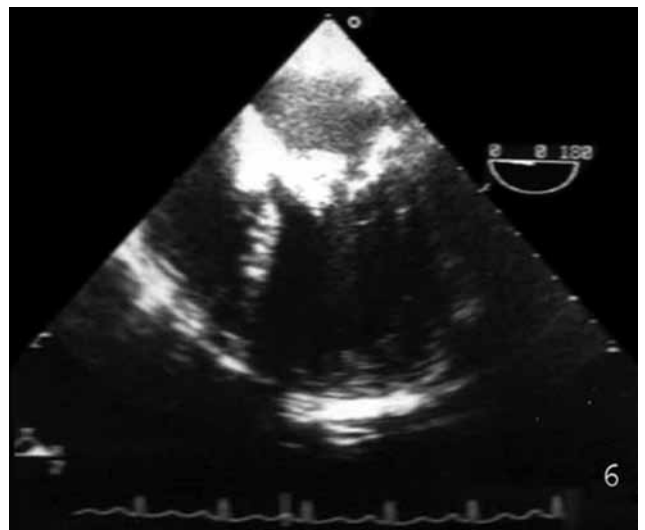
Image of mitral valve vegetation on transesophageal echocardiography.
